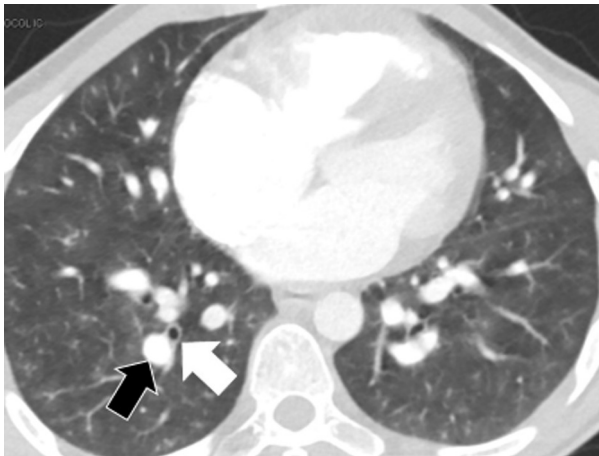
CT angiogram demonstrating increased segmental artery (black arrow) to bronchus ratio (white arrow).
